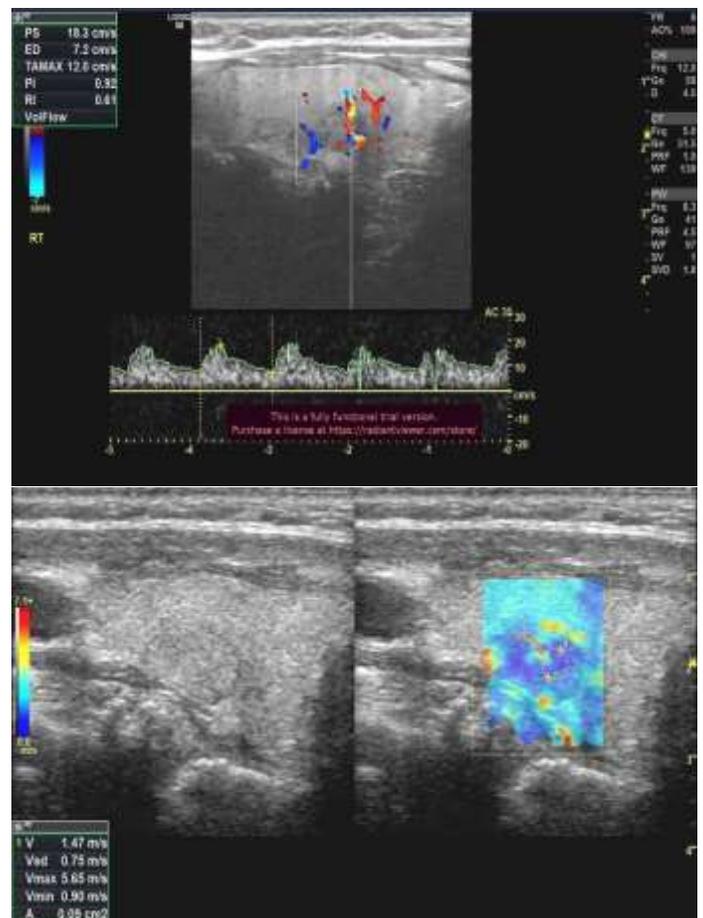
demonstrates RI measurement obtained from a representative intranodular feeding artery using spectral Doppler analysis. Figure 2b shows SWE assessment, in which the color-coded elastographic map represents shear-wave velocity distribution (with warmer colors indicating higher stiffness and cooler colors indicating lower stiffness). The region of interest (ROI) was manually adjusted to include the entire nodule while avoiding surrounding thyroid parenchyma, and mean shear-wave velocity (Vmean) and velocity standard deviation (Vsd) values were calculated accordingly.
